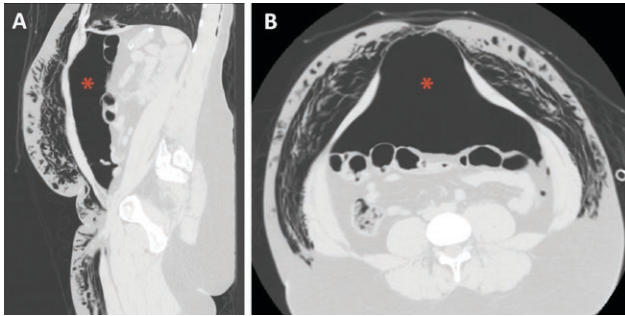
CT imaging demonstrating pneumoperitoneum (marked by red asterix).
